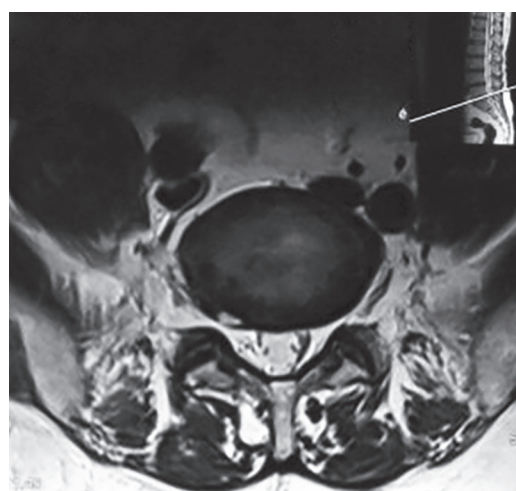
HIZ at L5-S1 disk level on T2-weighted MRI
